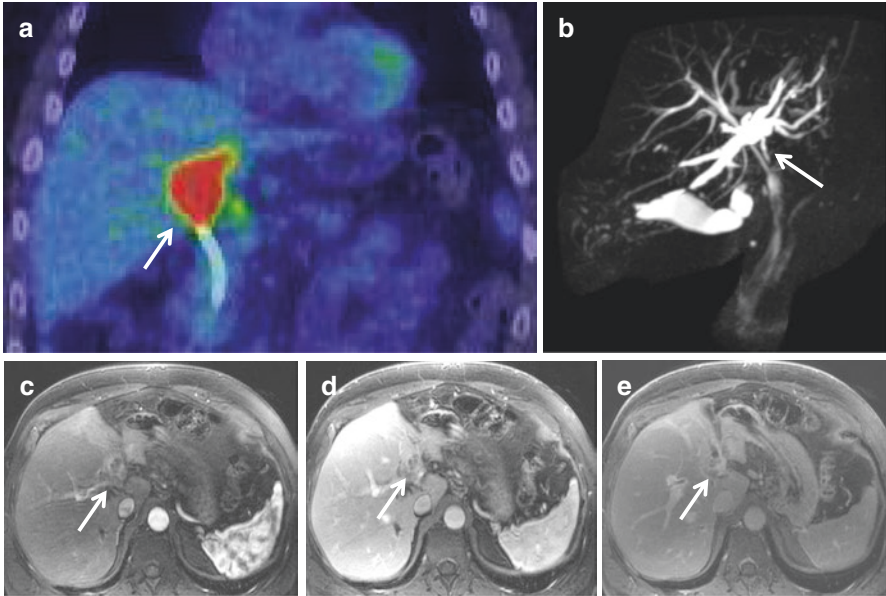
Perihilar cholangiocarcinoma—“Klatskin” tumor—evaluated with ^{18}F -FDG PET/CT and MRI/MRCP. (a) Coronal ^{18}F -FDG-PET/CT shows a hypermetabolic mass in the central liver (white arrow). (b) Coronal MIP MRCP shows dilatation of intrahepatic bile ducts beginning at the confluence of the left and right hepatic ducts secondary to an hilar obstructing mass and no filling of the extrahepatic bile duct (white arrow). (c–e) MRI shows an ill-defined mass in the porta hepatis that shows (c) peripheral arterial phase hyperenhancement (white arrow) and (d, e) slight progressive centripetal enhancement on (d) portal venous and (e) delayed phases (white arrow). ^{18}F -FDG 18F-fluorodeoxyglucose, PET positron emission tomography, CT computed tomography, MRI magnetic resonance imaging, MRCP magnetic resonance cholangiopancreatography, MIP maximum intensity projection
